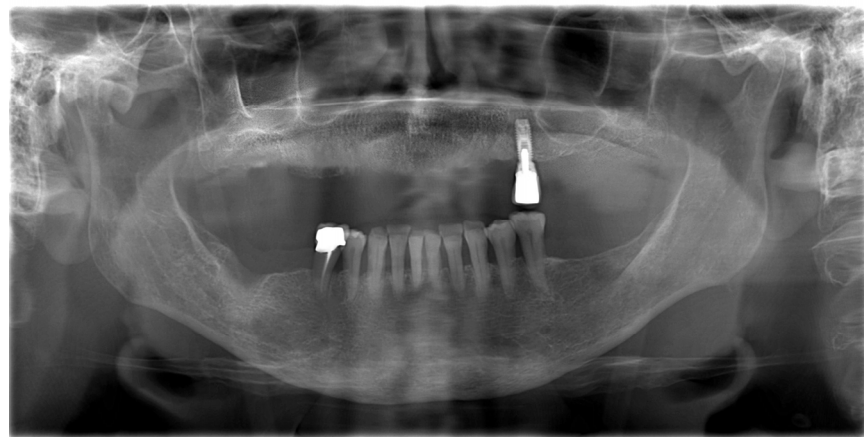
Panoramic radiograph at 4 months after tooth extractions. No signs of osteonecrosis were present. The post-extraction socket was completely healed.
